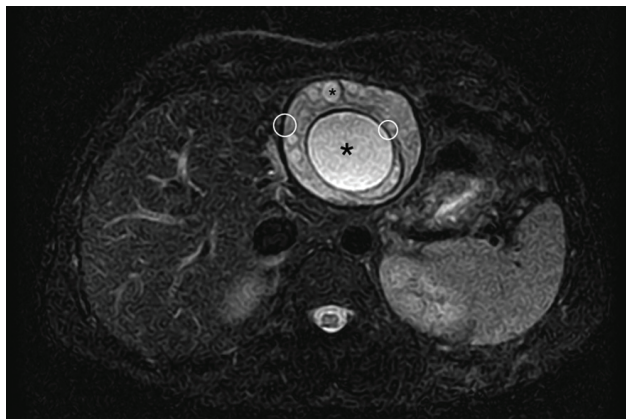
Axial T2 Trigger abdominal MRI shows a focal lesion in the left lobe of the liver with multiple rounded hyperintense lesions (asterisks) of cystic appearance, with a subtle hypointense rim corresponding to the signet ring sign (white circumferences). Gharbi type III-CE2.
